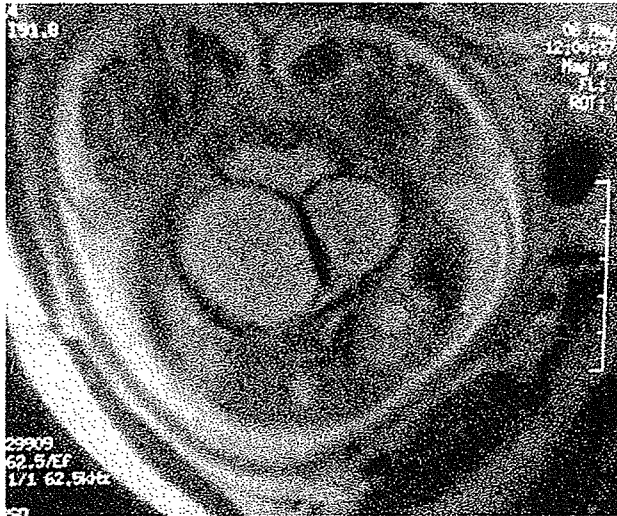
Demonstration of duplicated hydrocolpos behind the bladder on magnetic resonance imaging.
